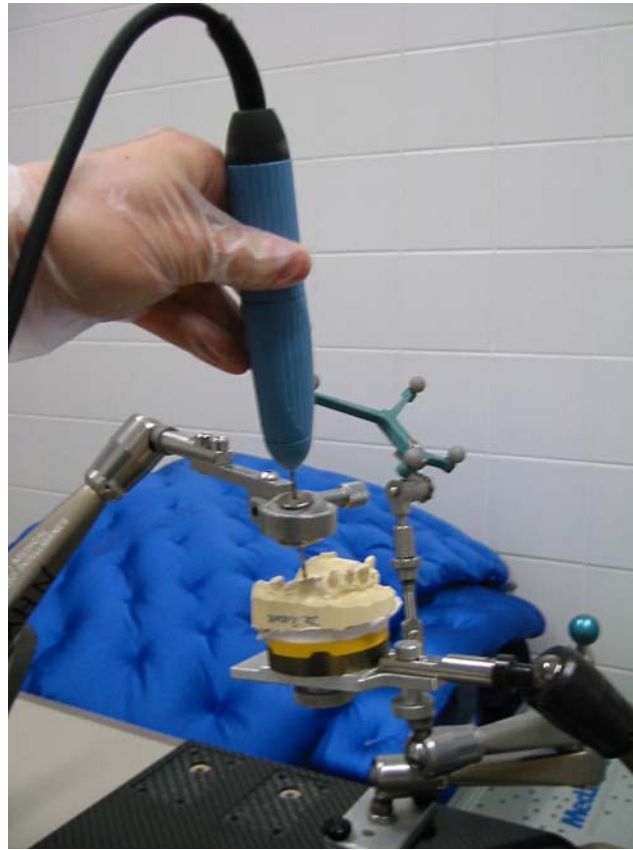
CT-guided template fabrication using a navigation system. Method 2. The aiming device of the navigation system is used to guide drillings into the dental stone casts, and the surgical bur tubes are indirectly positioned by metal rods inserted in the drill holes. The bur tubes are affixed in the surgical template in a single session in the dental laboratory.
